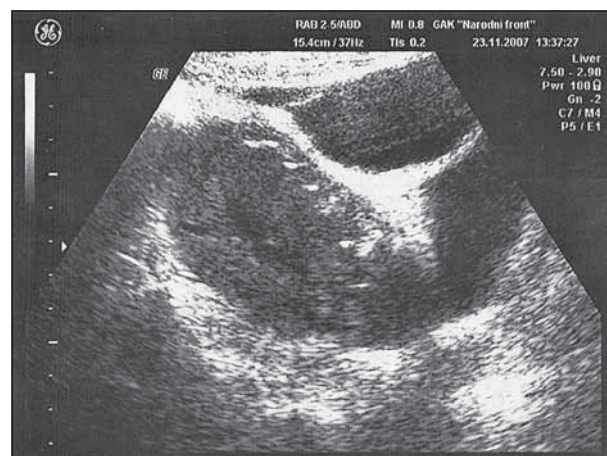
Ultrasound checking seven days after surgery
